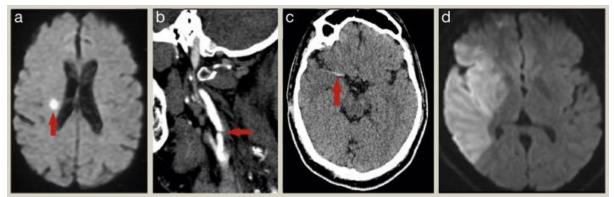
(a) Axial diffusion-weighted MRI showing an acute small subcortical infarction in the right centrum semiovale white matter consistent with a small vessel occlusion (red arrow). (b) Extracranial CT angiography demonstrating ≥95% carotid stenosis (red arrow). (c) Non-contrast axial CT of the brain showing acute thrombus in the right middle cerebral artery (the hyperdense MCA sign; red arrow). (d) Resulting acute infarction showing high signal indicating restricted diffusion on axial diffusion-weighted MRI of the brain.
